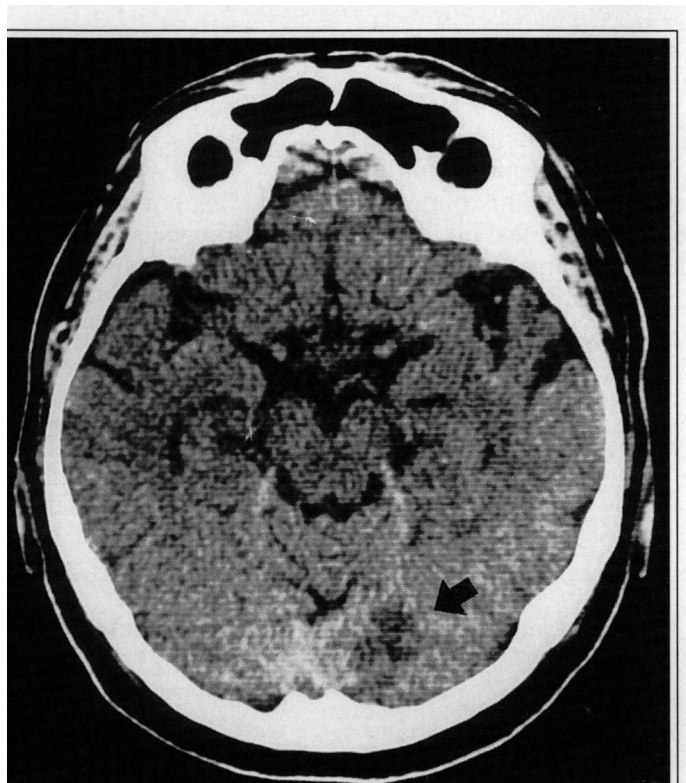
CT scan showing hypodensity in the right occipital lobe (black arrow).
